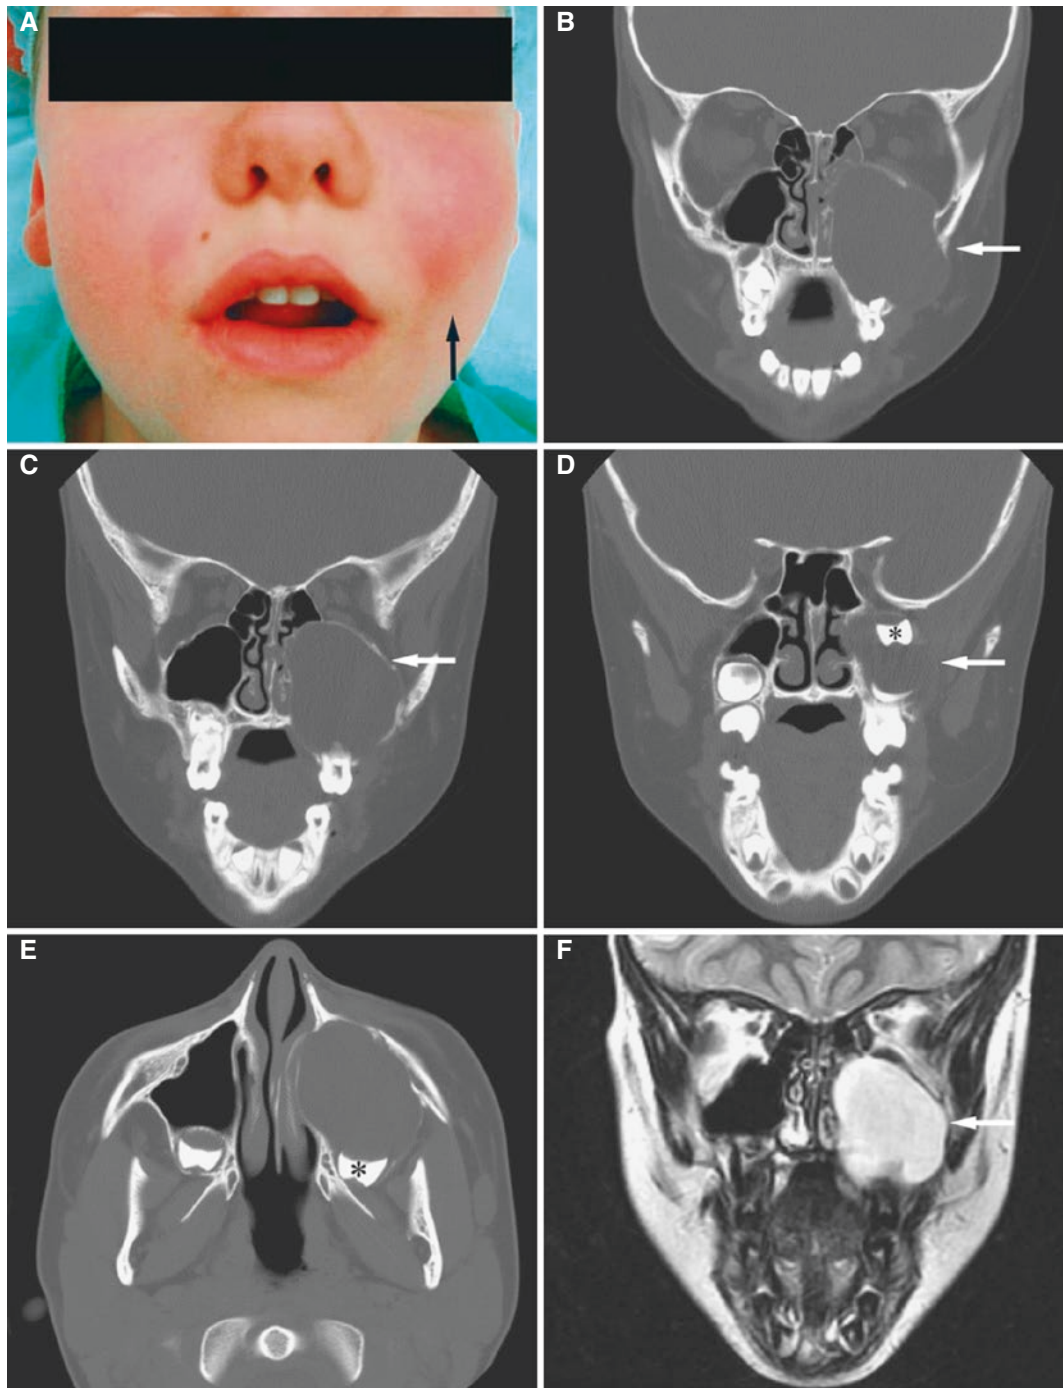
Maxillary follicular (dentigerous) cyst; 7-year-old male with painless facial swelling. (A) Clinical photograph before surgery shows facial swelling (*arrow*). (B) Coronal CT image shows cyst (*arrow*) filling the entire left maxillary sinus and most of the left nasal cavity and extending into the ethmoid cells, hard palate, and facial soft tissues. (C) Coronal CT shows corticated outline (*arrow*) and root resorption. (D) Coronal CT image shows cyst (*arrow*) with impacted tooth (*asterisk*) displaced to cranial part of the maxillary sinus. (E) Axial CT image shows impacted tooth (*asterisk*) with follicular cyst
